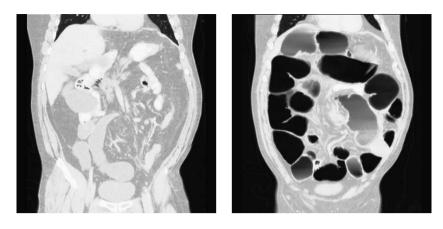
CT scan showing a closed-loop small bowel obstruction with 2 transition points.
